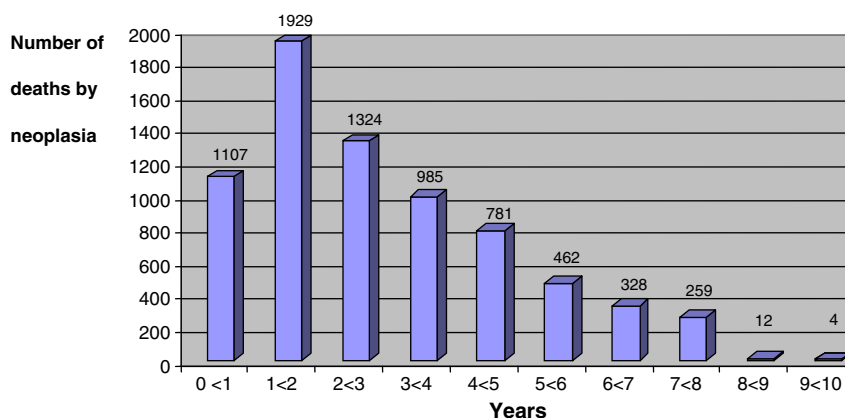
Distribution of the number of deaths by neoplasia versus duration of exposure since the date that the first antenna in each analyzed CT came into operation.
